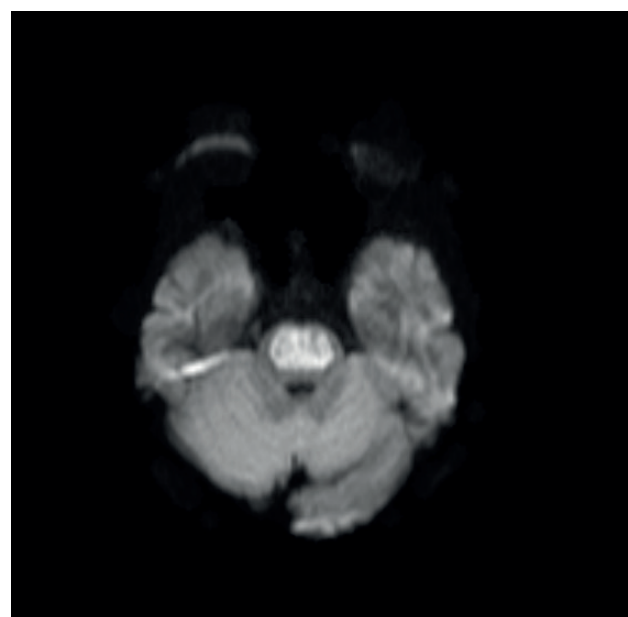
DWI image showing hyper intense signal.
